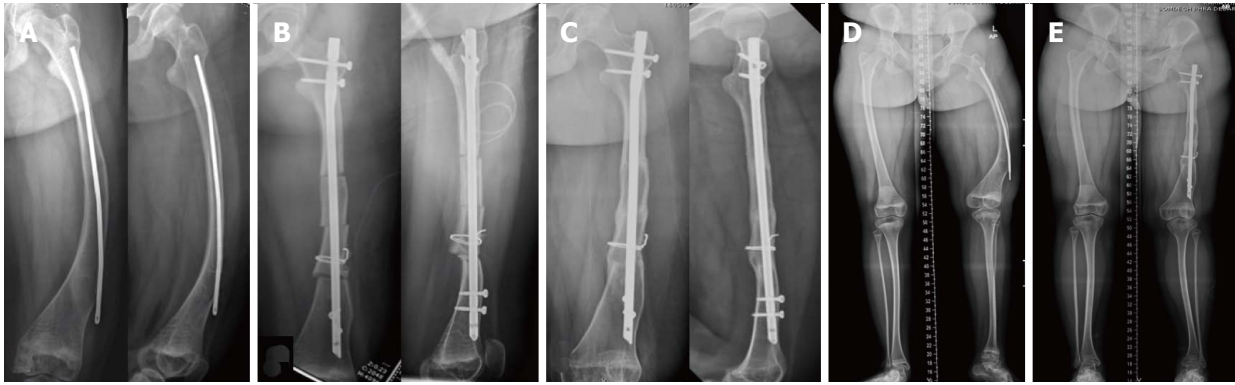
Clinical presentation of case 1. A 12-year-old girl with type I osteogenesis imperfecta presented with progressive bowing of left shaft femur after ender nail fixation for 3 years. Plain radiographs of left femur in anteroposterior and lateral views on preoperative period (A), immediately after multi-level osteotomy and internal fixation with humeral nail (B), 9-mo after humeral nail fixation (C), preoperative scanogram (D) compared with 1-year postoperative scanogram (E).
